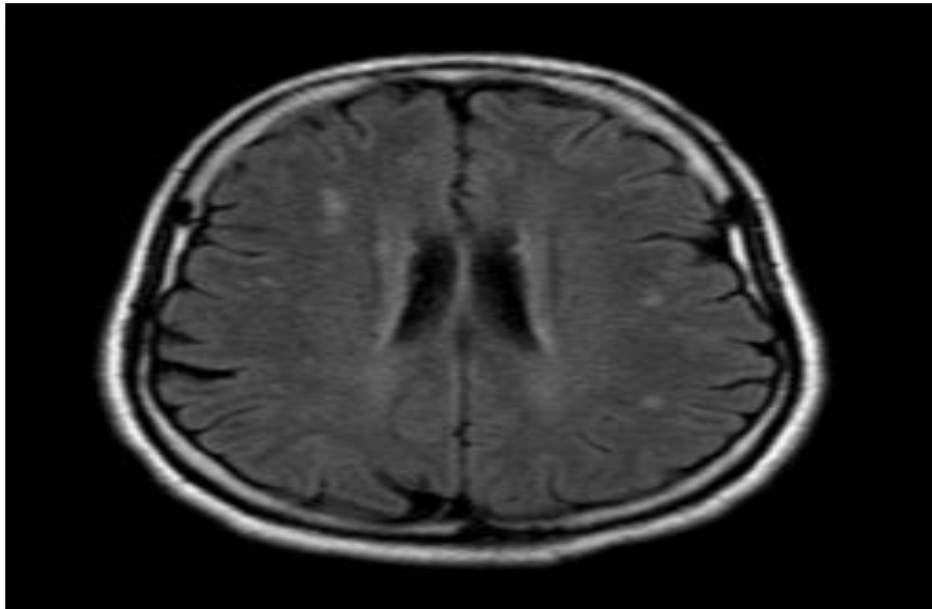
(a): A 43-year-old well-known case of RRMS female patient presented by quadriparesis; axial Brain FLAIR shows multiple bilateral hyperintense discrete and confluent plaques seen at the posterior frontal subcortical white matter with one of them is seen at the U fibers seen at the LT side.
